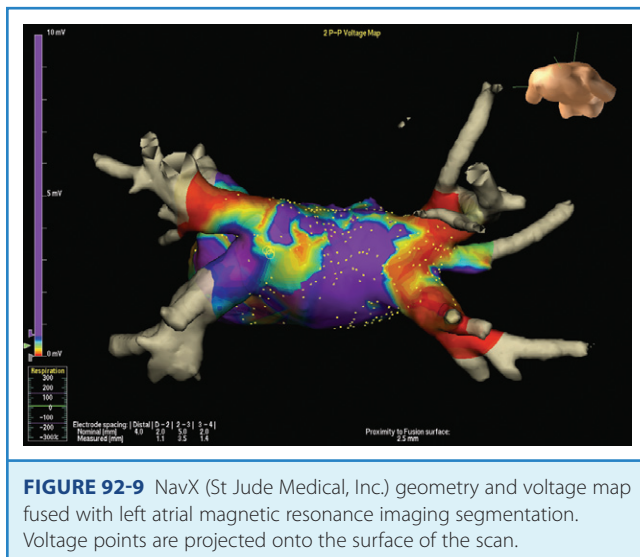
NavX (St Jude Medical, Inc.) geometry and voltage map fused with left atrial magnetic resonance imaging segmentation. Voltage points are projected onto the surface of the scan.
